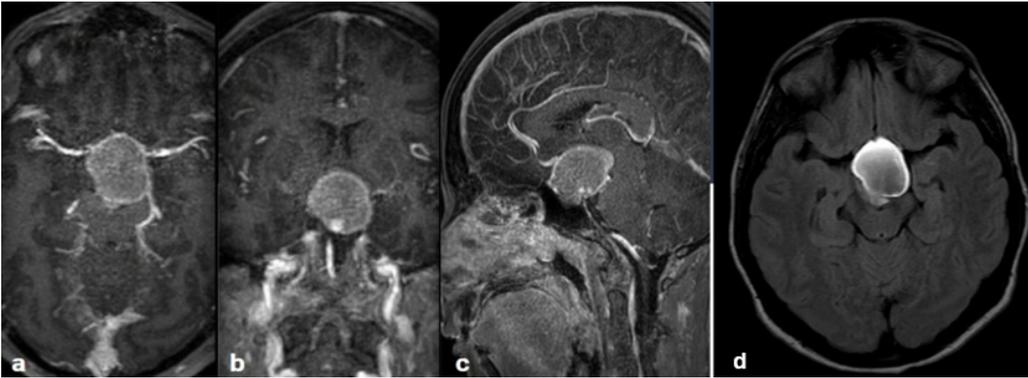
MRI of the brain with contrast in axial (a), coronal (b), and sagittal (c) views. A cystic lesion of approximately 3.2 cm is observed in the sellar and suprasellar region, compressing the optic chiasm and the structures adjacent to the suprasellar cistern. Axial T2 FLAIR sequence image (d) showing cystic lesion with hyperintense signal.
